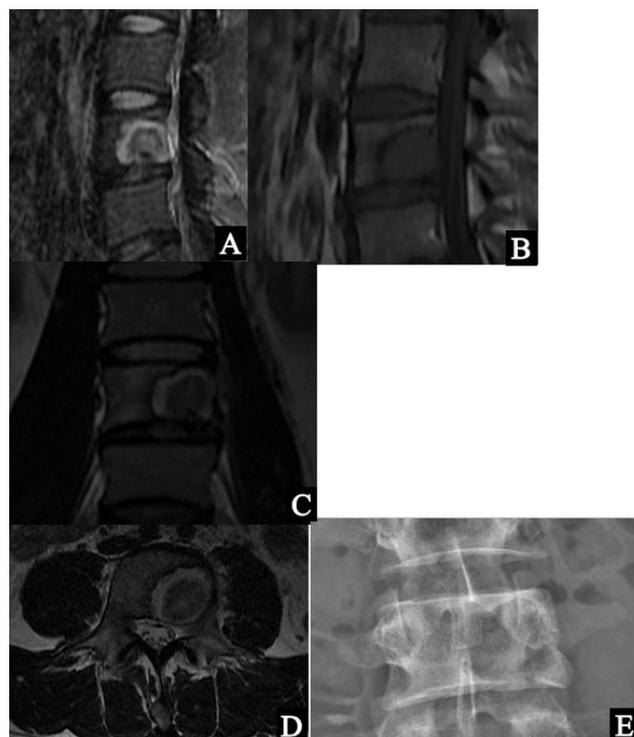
Tuberculous focus in VL4 vertebral body. MRI A- sagittal fat-suppressed T2 weighted; B – sagittal T1 weighted; C – frontal T2 weighted; D- axial T2 weighted. E – plain X-ray
